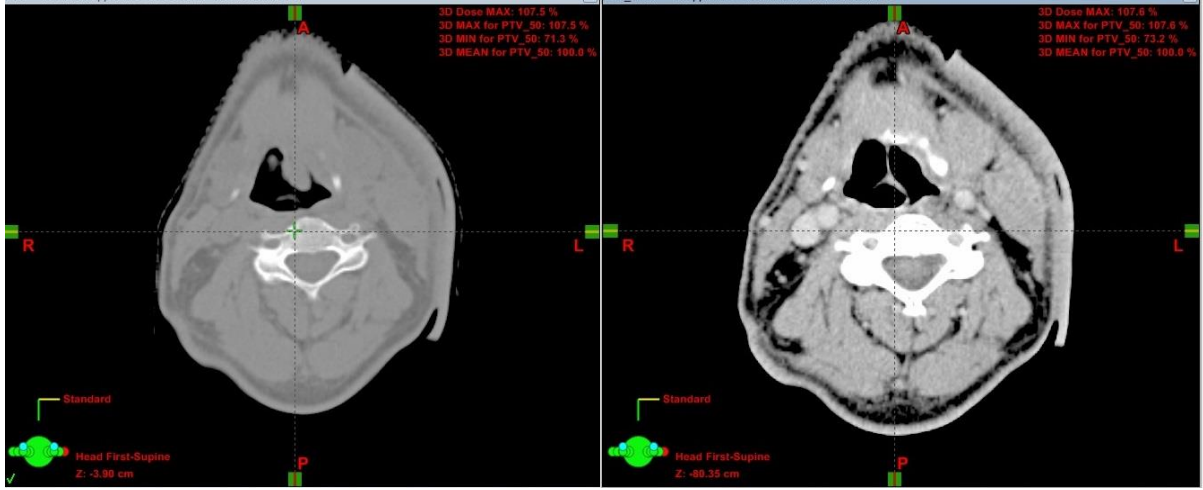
CT scans made before (left) and after (right) administration of contrast material
